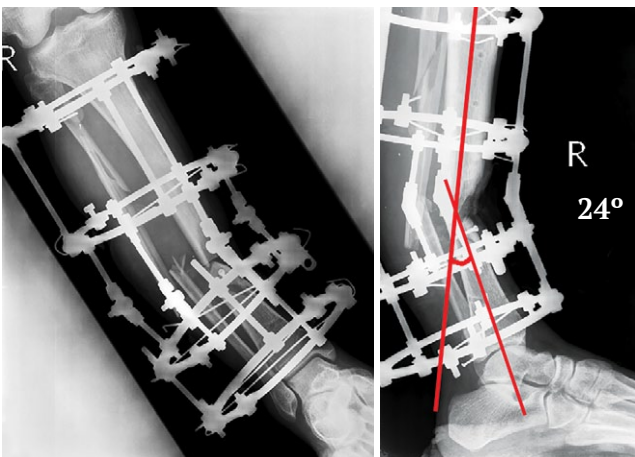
X-rays of the lower leg in frontal and lateral projections after fixation with the Ilizarov hinged-distraction apparatus, the recurvation angle was 24°
